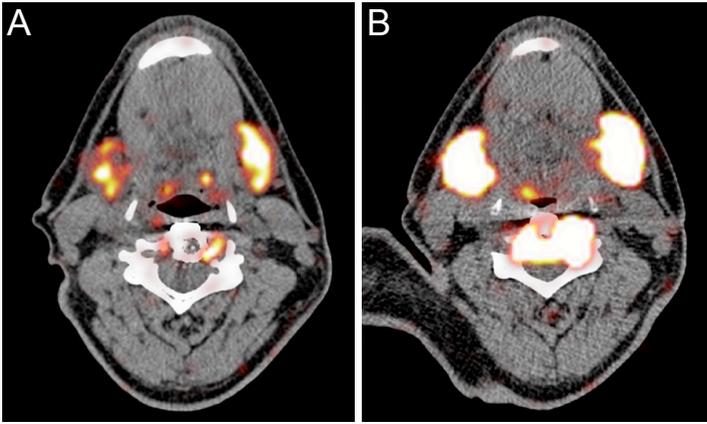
^{124}I PET/CT with increased uptake of ^{124}I in metastatic lesion in C4 after THW (B) compared to rhTSH (A).
